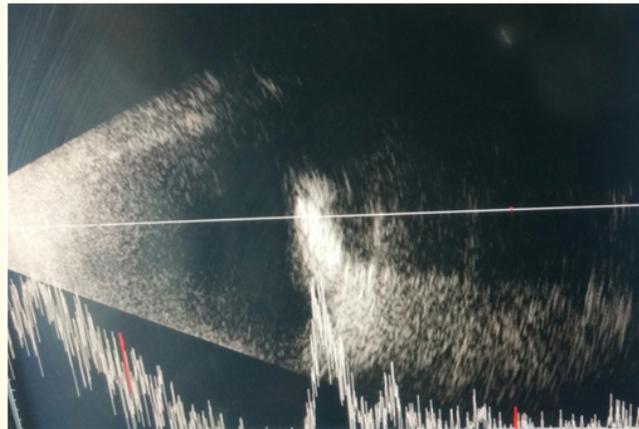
B-scan ultrasonography shows slightly elevated choroidal mass with high reflectivity and acoustic shadowing.
